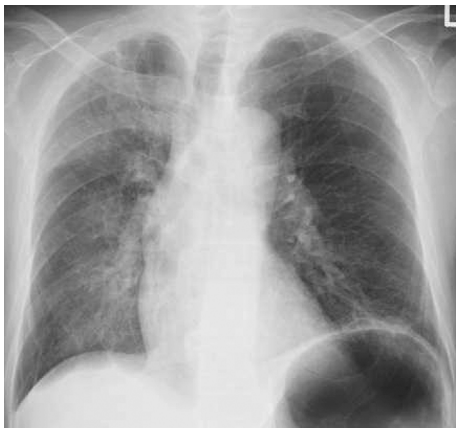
Chest X-ray on 52 day of hospitalization showed that the consolidation in the right lower lung field significantly improved. The patient was discharged from our hospital following these findings.
